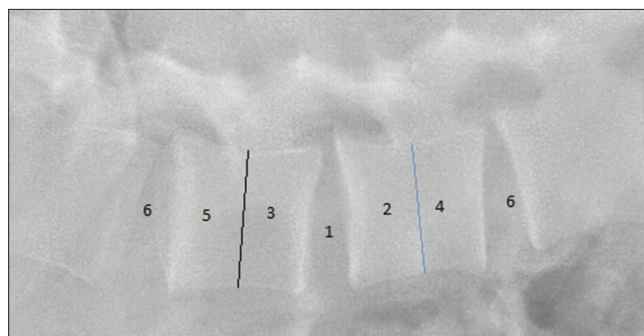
Depicting the method of analysis of X-ray
